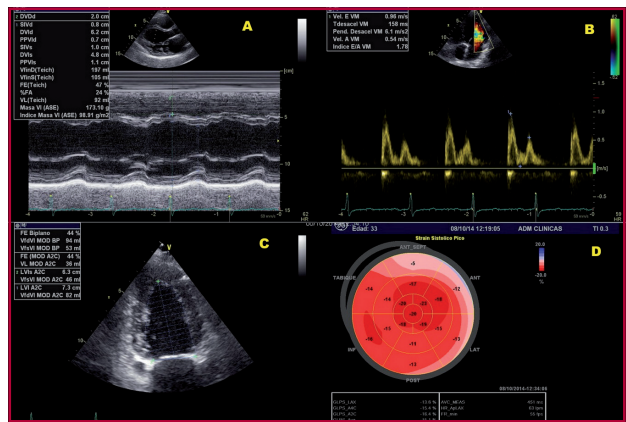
Echocardiographic image showing left ventricular dilatation (A) with moderate diastolic dysfunction (B) and moderate left ventricular dysfunction (C)
